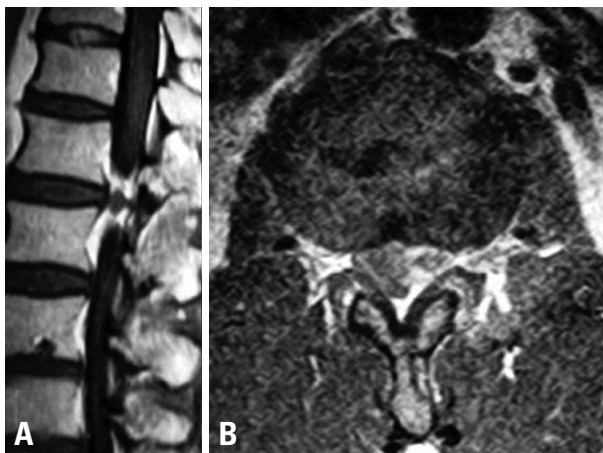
Preoperative enhanced MRI (A: sagittal, B: axial), showing a ring-enhanced mass at the L1-L2 level.
